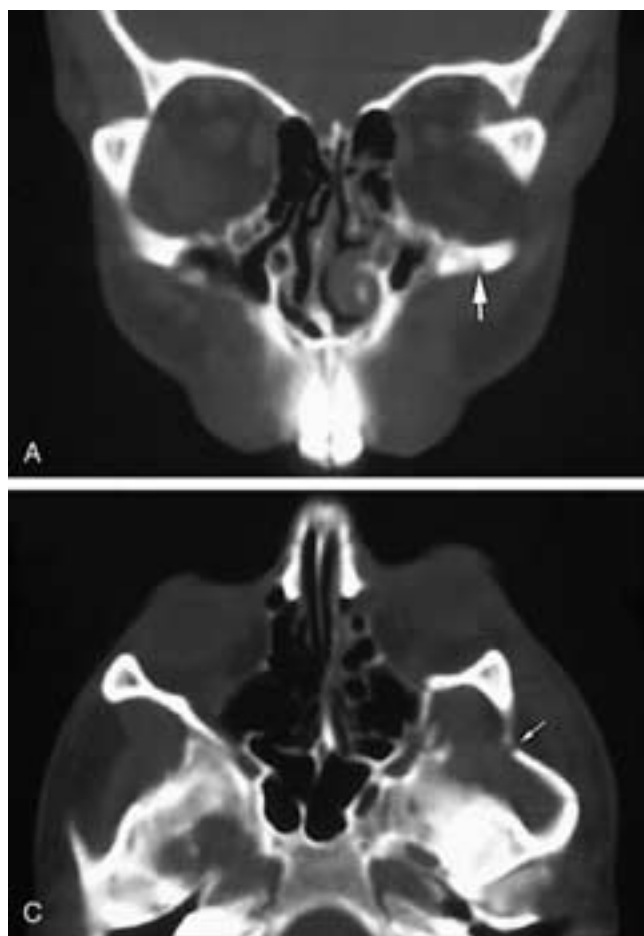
Coronal (A), axial (B), and more caudal axial (C) CT scans show a variant of the classic trimalar fracture. The lateral orbital wall is dorsally displaced and rotated counterclockwise. The zygomatic arch is also fractured (*small arrow* in C). Rather than the more common fracture, which extends through the zygomaticomaxillary suture region, this fracture extends through the lateral zygoma or lower lateral orbital wall (*large arrow* in A).
